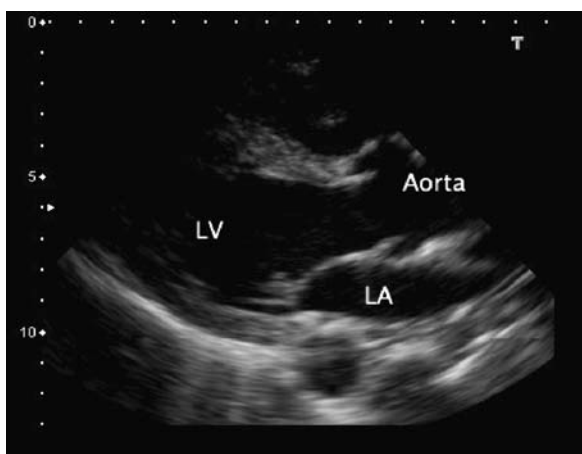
Parasternal long axis view of the heart in systole. Note that aortic valve is fully opened and the mitral valve is closed
